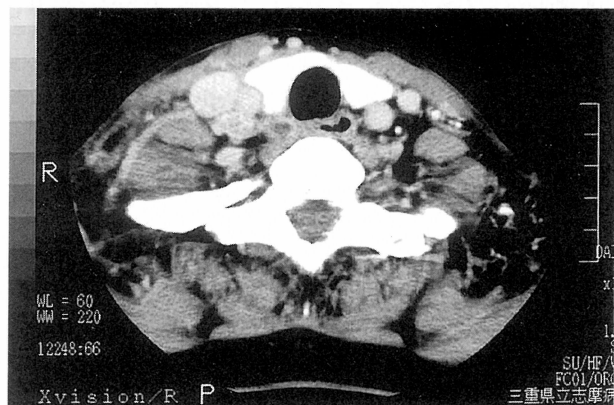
CT scan revealed a recurrent tumor of the neck lymph node before (2/a) and after (2/b) chemotherapy.
